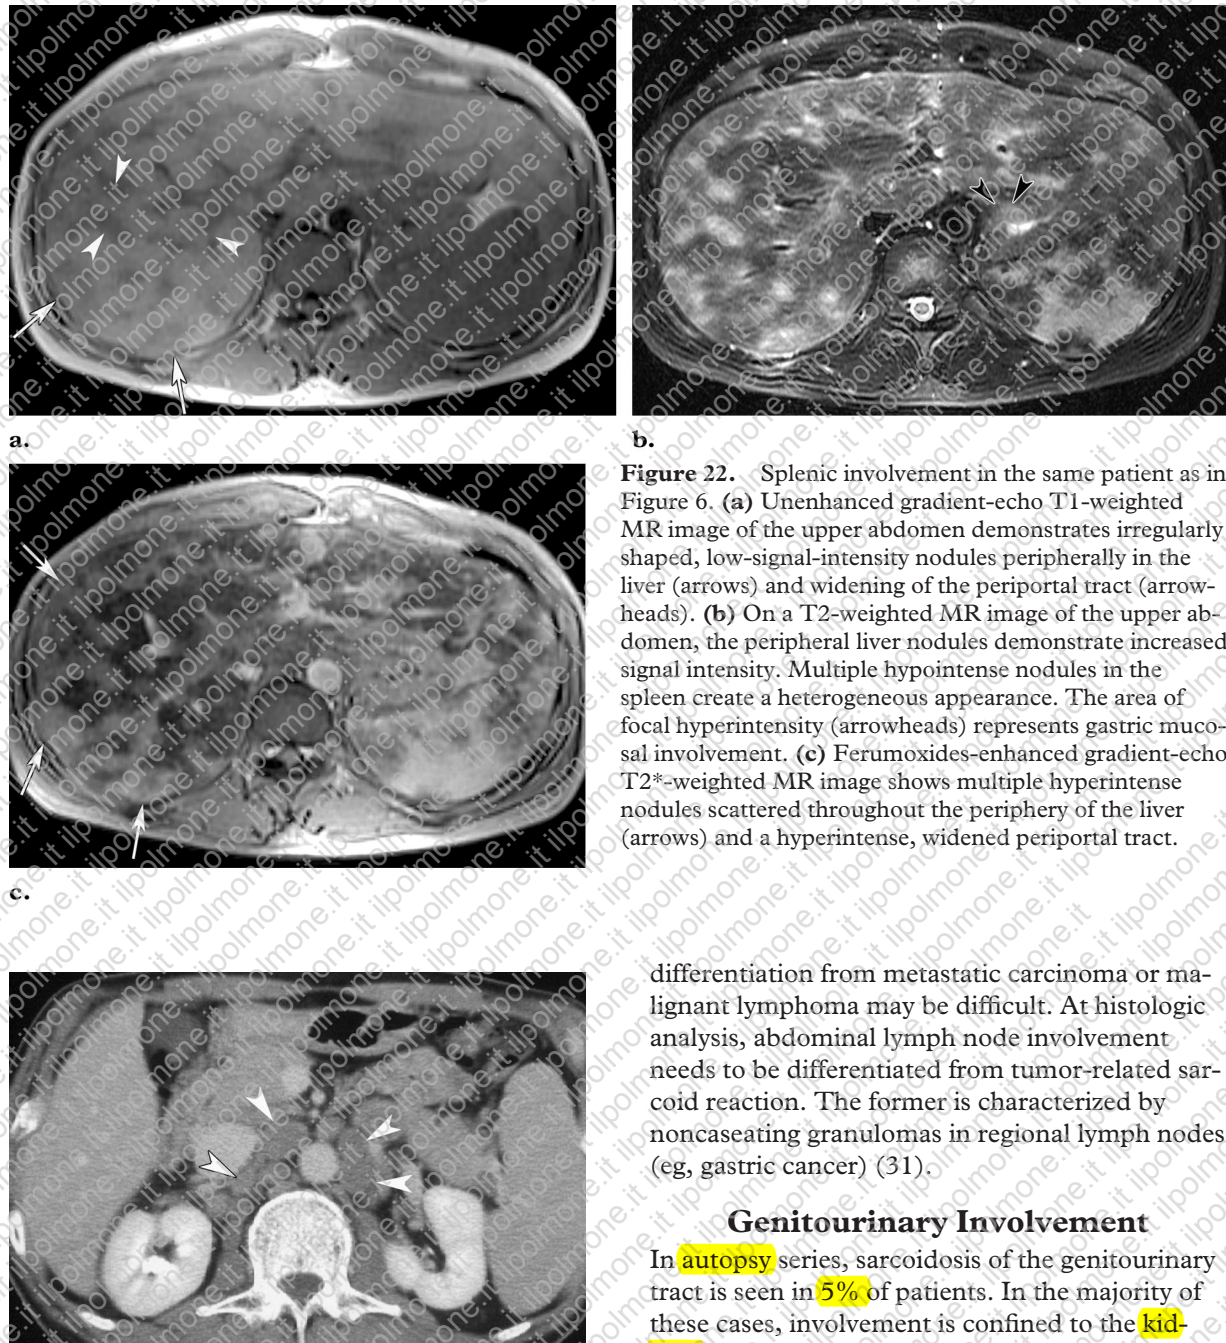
Lymphadenopathy in the paraaortic region in the same patient as in Figure 9. Contrast-enhanced abdominal CT scan shows multiple paraaortic areas of adenopathy (arrowheads) that mimic lymphoma or metastases.
